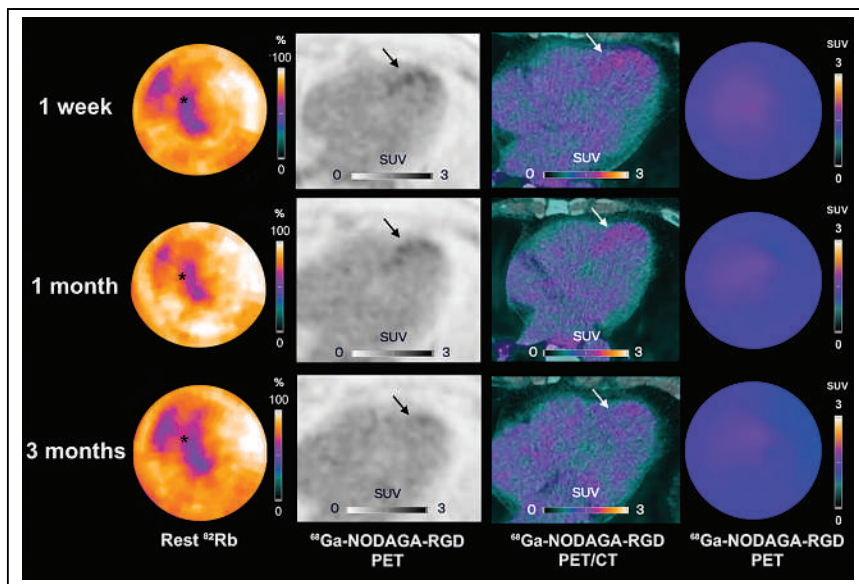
Participant example with decrease in $\alpha_v\beta_3$ integrin expression levels (arrows) in infarcted myocardium (asterisks) after 1 wk to follow-up at 3 mo. Shown are rest ^{82}Rb , ^{68}Ga -NODAGA-RGD PET, and ^{68}Ga -NODAGA-RGD PET/CT images at 1 wk (first row), 1 mo (second row), and 3 mo (third row) after STEMI.
